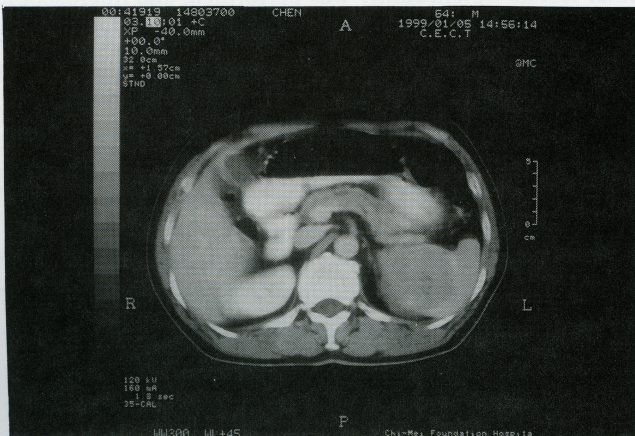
Splenic mass shown as a round, slightly enhanced lesion on postcontrast CT scan.
